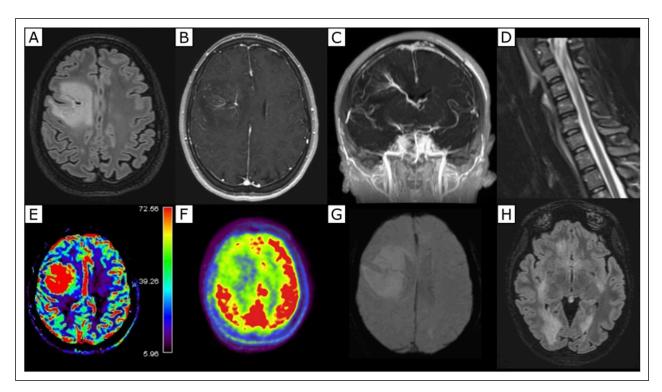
(A) FLAIR ponderated sequence, showing a massive tumefactive inflammatory lesion in the right frontal lobe. (B) Gradient-echo T1 ponderated sequence with gadolinium, showing the right frontal lobe DVA. (C) Frontal maximum intensity projection (MIP) showing the same DVA. (D) Short TI Inversion recovery sagittal sequence, showing an hyper-T2 lesion in the medullar cord at C3-C4 level. (E) rCBV map, showing a massive increase in relative blood volume in the area of the DVA and inflammatory lesion. (F) FDG-PET scan showing a decrease in brain glucose intake in the right frontal lobe. (G) SWI MIP sequence, showing a relatively low vascular hyposignal in the area of the DVA. (H) FLAIR ponderated sequence, showing multiples other ADEM lesions in hypersignal trough the brain.
